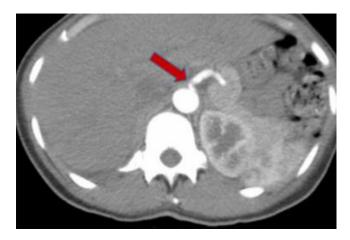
Axial abdominal CTA image demonstrates narrowing of the proximal celiac axis (red arrow). There is minimal post stenotic dilatation, characteristic of median arcuate ligament syndrome. (Color version available online.)
